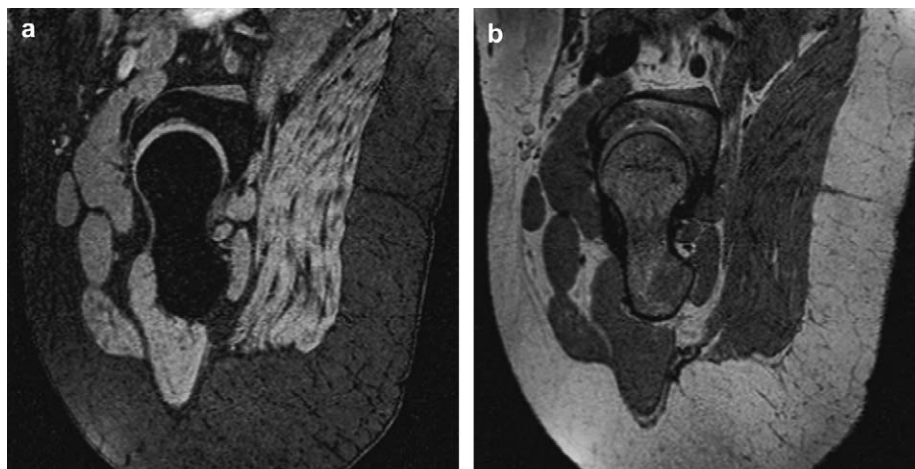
Corresponding oblique sagittal slices from 3D MR image sets of the right hip using (a) a fat-suppressed 3D gradient echo and (b) a T_2 -weighted 3D gradient-echo sequence.
